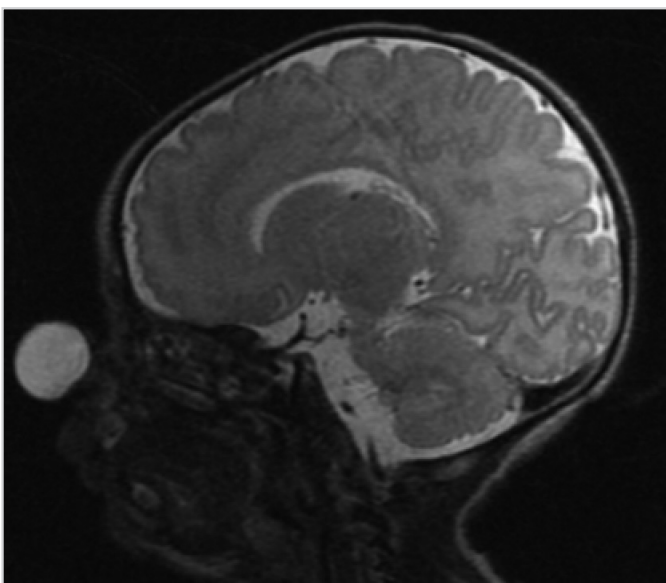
Sagittal T2 MRI view of the lesion
